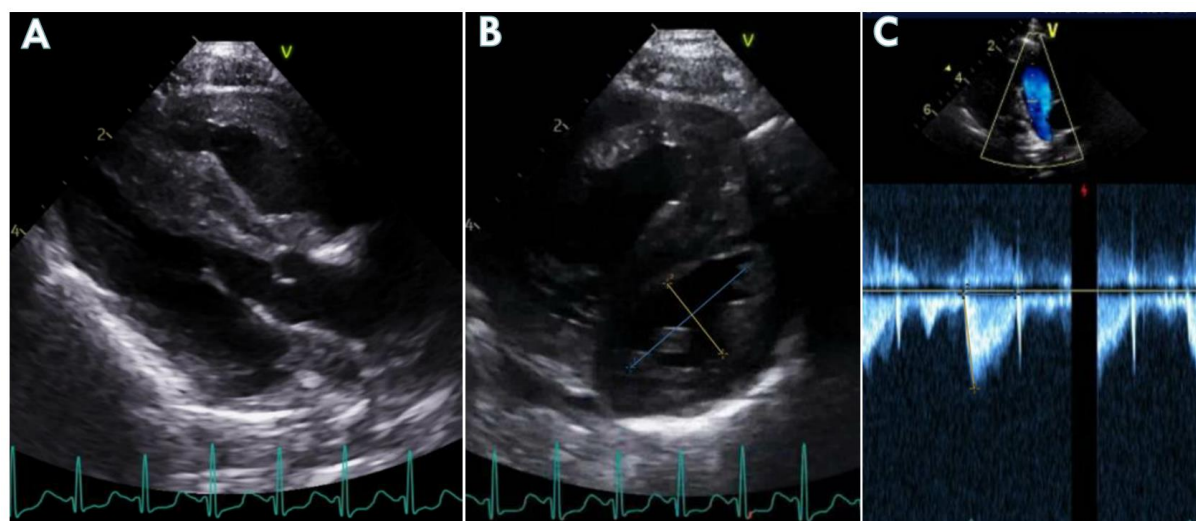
Echocardiography findings. A – Parasternal long axis showing the RV hypertrophy. B – Parasternal short axis view of the ventricles demonstrating septal flattening and an increased Eccentricity Index (>1.3). C – Pulse Wave Doppler of the RV outflow tract demonstrating a PAAT/RVET <0.3 .
